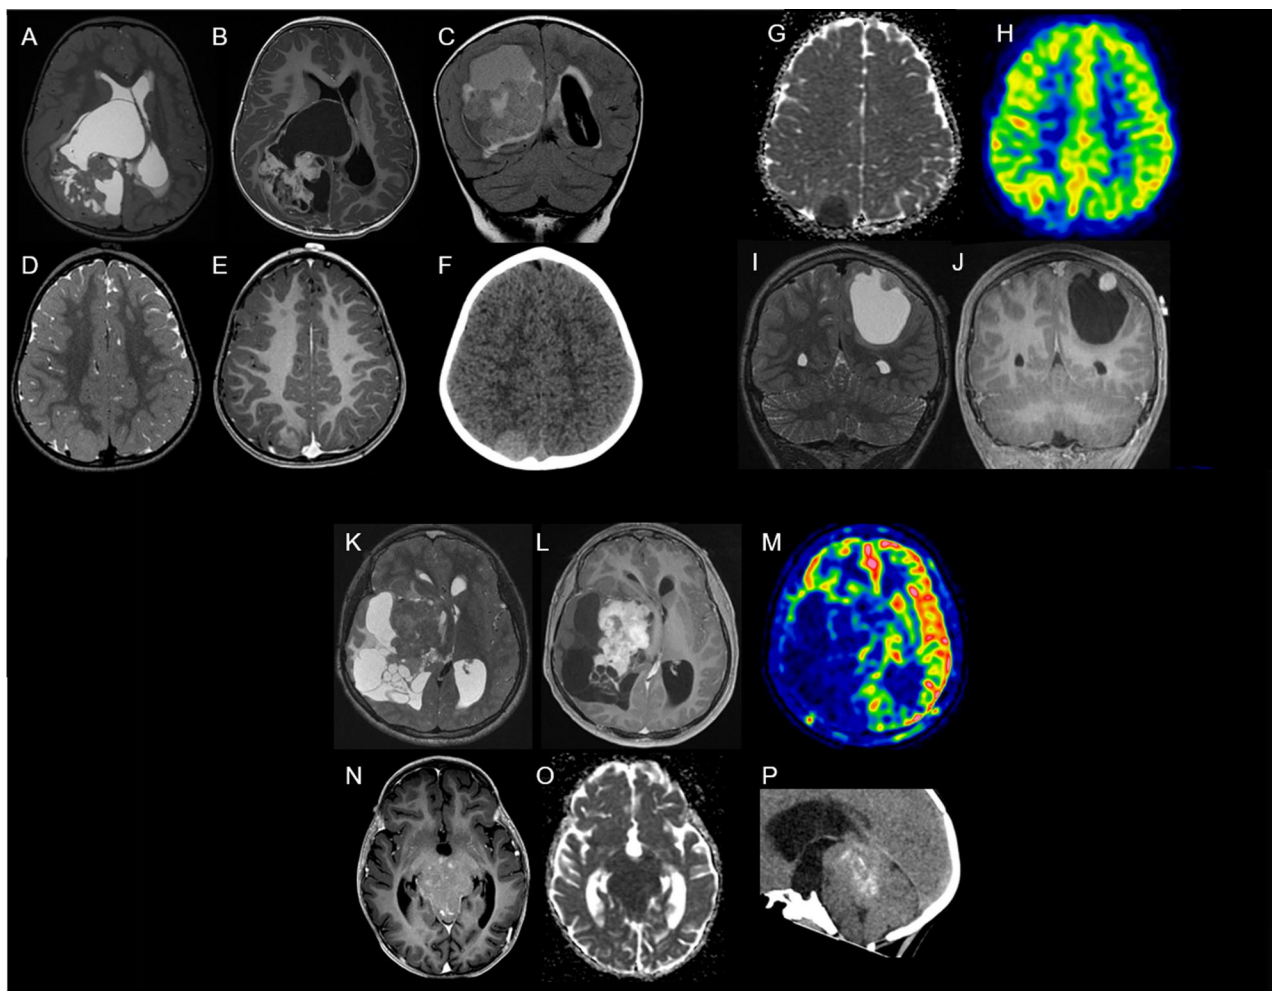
Imaging features of neuroepithelial tumors, *PATZ1*-fused. A–C Imaging of patient #1 on axial T2-weighted (A), post-contrast T1-weighted (B) and coronal FLAIR (C) images, showing a large heterogeneous right intraventricular mass with cystic content and contrast enhancement. D–H Imaging of patient #2 on axial T2-weighted (D), post-contrast T1-weighted (E), unenhanced CT (F), apparent diffusion coefficient map (G) and cerebral blood flow map (H) images, showing a right parietal mass with solid content, partial contrast enhancement, high density, diffusion restriction and low tumoral blood flow. I–J Imaging of patient #3 on coronal T2-weighted (I) and post-contrast T1-weighted (J) images, showing a left parietal cortical mass with a large cyst and a small enhancing nodule. K–M Imaging of patient #7 on axial T2-weighted (K), post-contrast T1-weighted (L) and cerebral blood flow map (M) images, showing a large heterogeneous right temporal mass involving the basal ganglia, with cystic content, contrast enhancement and low tumoral blood flow. N–P Imaging of patient #8 on axial post-contrast T1-weighted (N), apparent diffusion coefficient map (O) and sagittal unenhanced CT (P) images, showing a partially calcified mass, with low contrast enhancement and strong diffusion restriction that developed from the tectal region through the tentorial incisura
